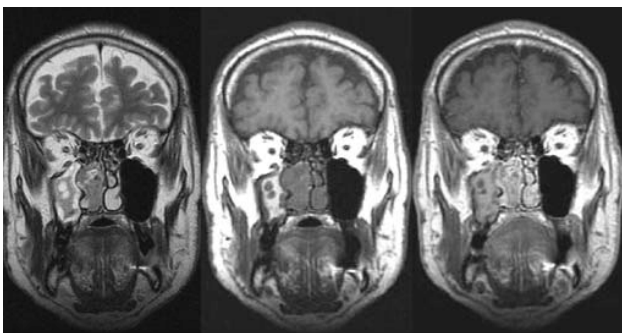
MR imaging of the paranasal sinuses showing T2-weighted, T1-weighted, and post-contrast T1-weighted coronal images demonstrating differential signal intensity and contrast enhancement patterns between right maxillary sinus mucosal thickening and a right nasal cavity polyp. [28]
